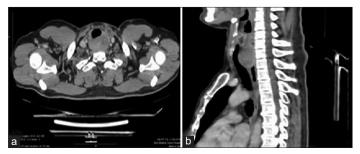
Computed tomography scan showing an exophytic mass arising from cervical esophagus. (a) Axial view; (b) sagittal view
